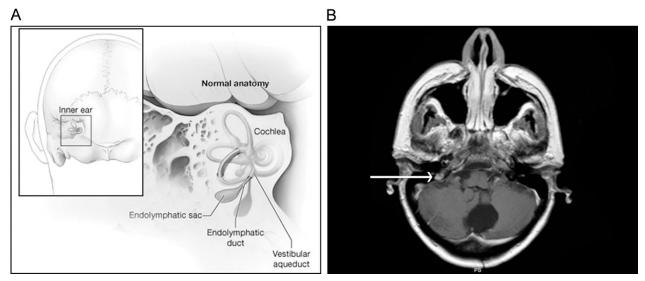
Endolymphatic sac tumor. A, Anatomic location of the endolymphatic sac. B, Subject 1: contrast enhanced T1-weighted MRI image of a right-sided endolymphatic sac tumor (arrow).
